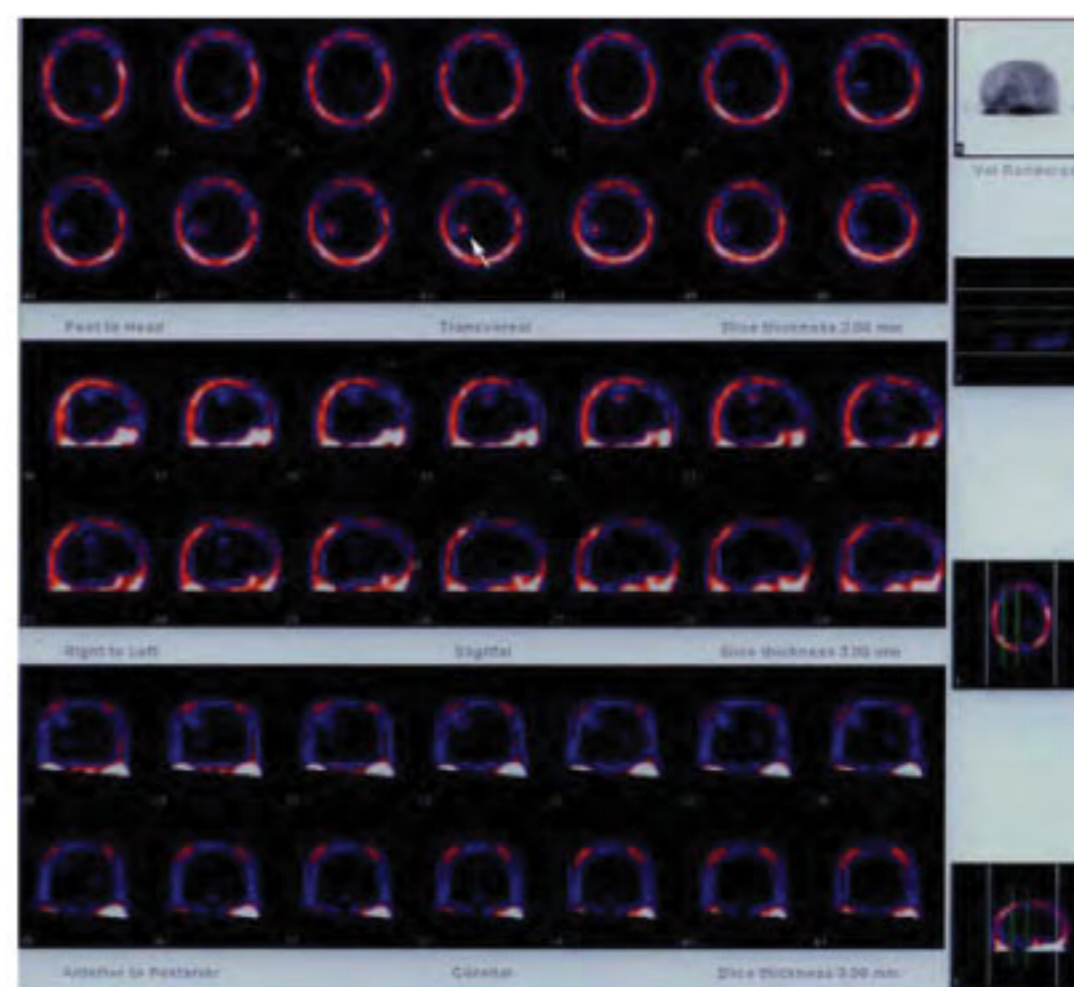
A 40 years old male with grade III astrocytoma. The lesion displays intense ^{99m}Tc -tetrofosmin uptake on SPET scintigraphy (arrow). The tracer uptake index (UI) obtained was 39.1.
